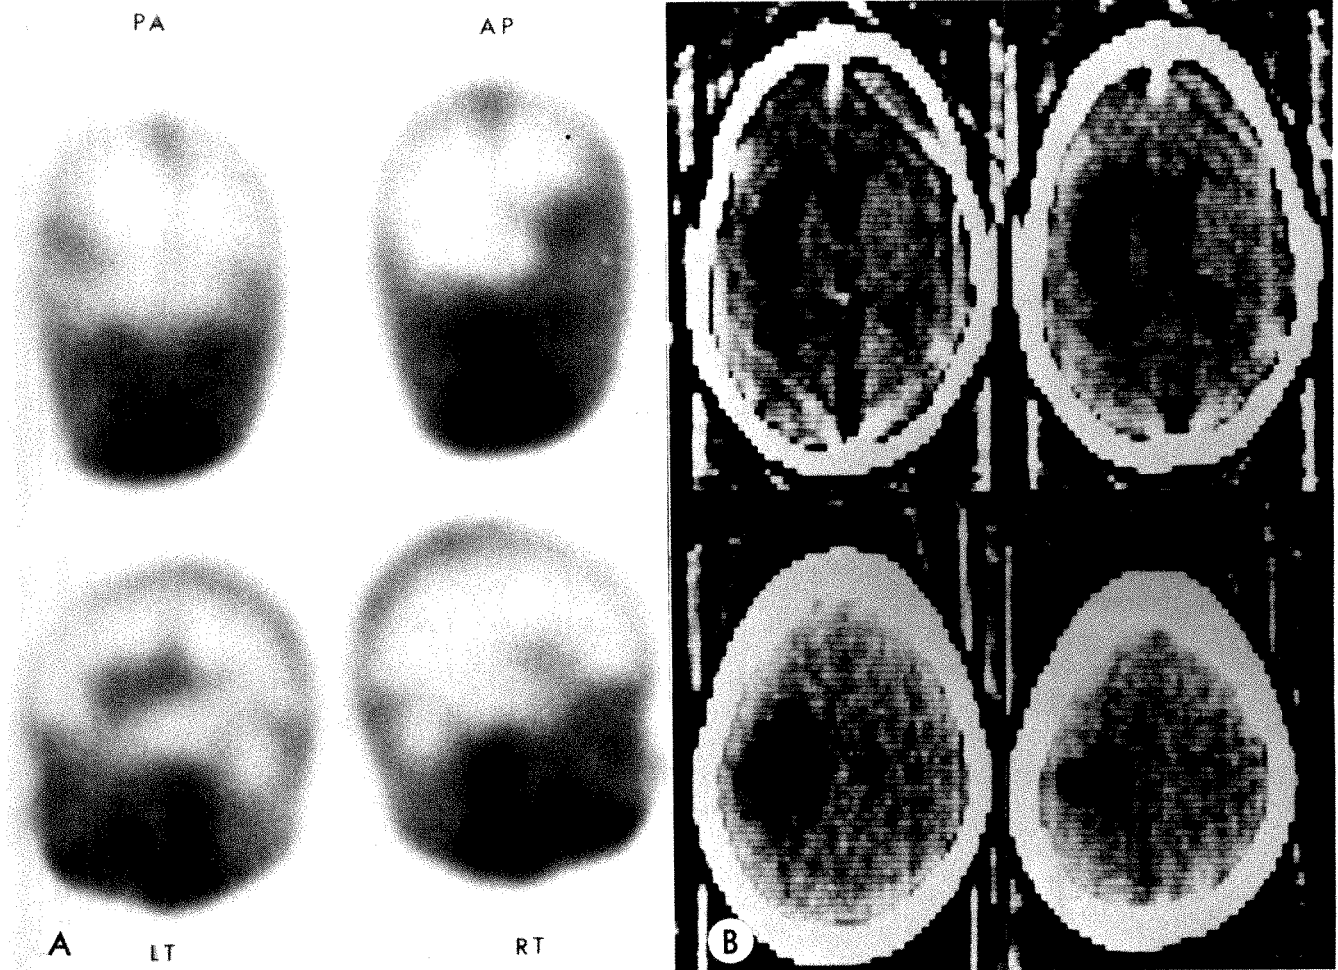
48-year-old woman with sudden right hemiplegia 3 weeks after pelvic surgery. Negative dynamic radionuclide scan; 2 months later static scan returned to normal. *A*, Static radionuclide scan showing increased uptake in area supplied by left MCA. Fan-shaped pattern best seen on left lateral projection. *B*, CT scan demonstrating well defined area of decreased density in region supplied by left MCA.
